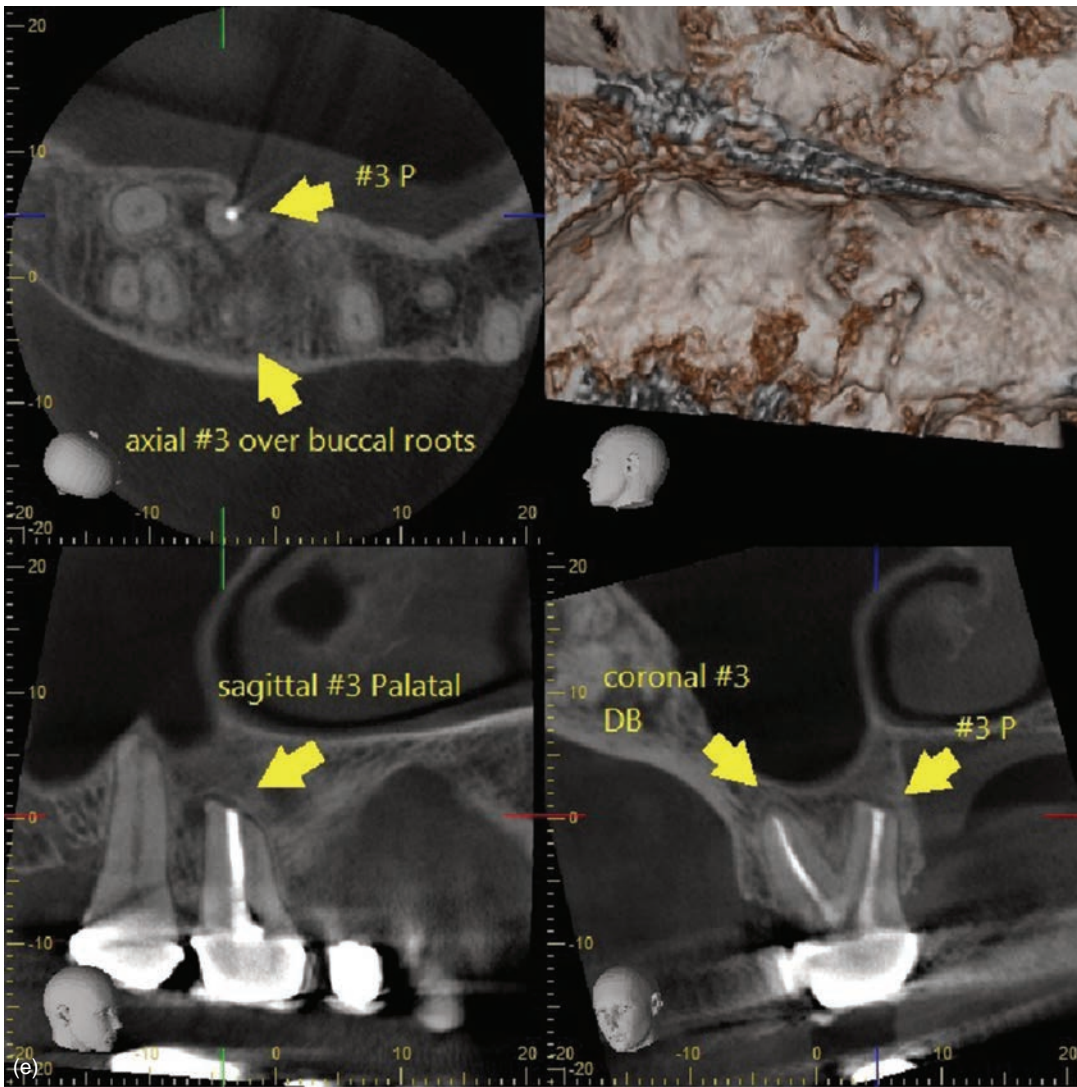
(Continued) (d) One year follow-up. (e) One year follow-up CBCT images of the surgical site showing cortical bone healing and reconstitution of PDL space.
